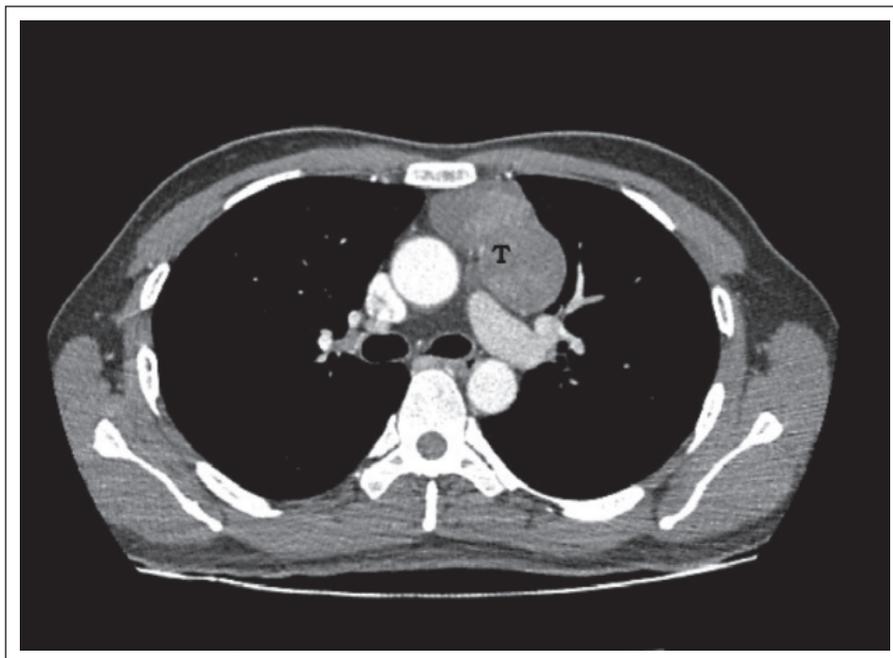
Contrast enhanced CT scan thorax revealed a lobulated heterogeneous enhancing anterior mediastinal mass indicating thymoma (T).
